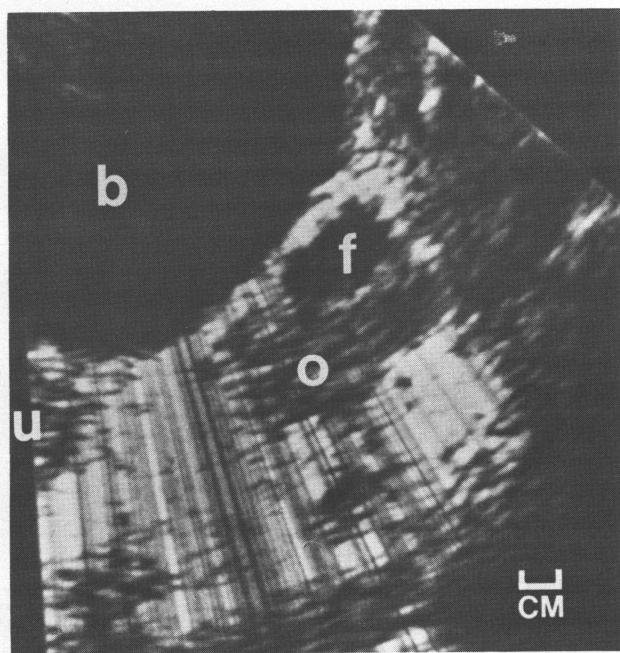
Pelvic ultrasound (case 1). *b*, Bladder; *u*, uterus; *o*, left ovary; *f*, follicle.
